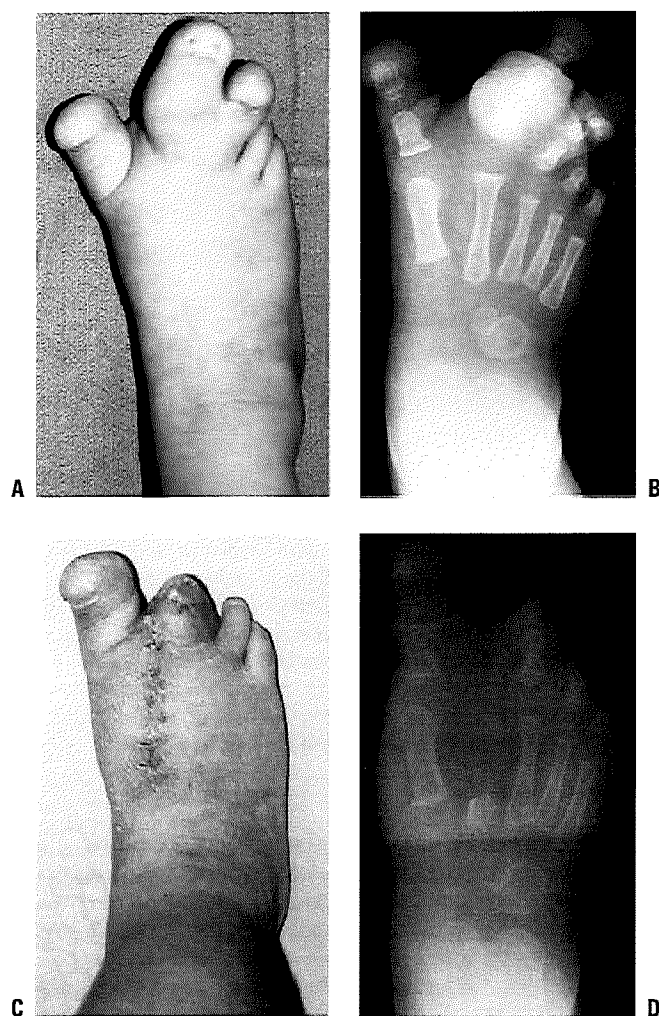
A: Macrodactyly most commonly involves the second ray; in this case, the hallux and third toe are involved to some degree. B: Radiographic appearance demonstrates enlargement of bone as well as soft tissue. C: Clinical appearance after second ray resection and third toe interphalangeal joint disarticulation. D: Radiographic appearance 1 year later. (From the private collection of Vincent S. Mosca, MD.)
